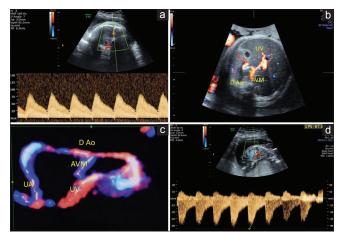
Ultrasound images of intrahepatic arteriovenous malformation. (a) Middle cerebral artery Doppler showing low resistance flow. (b) Color Doppler showing anomalous connection between descending aorta and inferior vena cava. (c) Four-dimensional rendered image of arteriovenous malformation between descending aorta and umbilical vein. (d) Longitudinal section of fetal abdomen showing anomalous arteriovenous connection with high-velocity flow. D Ao: Descending aorta, UV: Umbilical vein, UA: Umbilical artery, AVM: Arteriovenous malformation, PSV: Peak systolic volume
